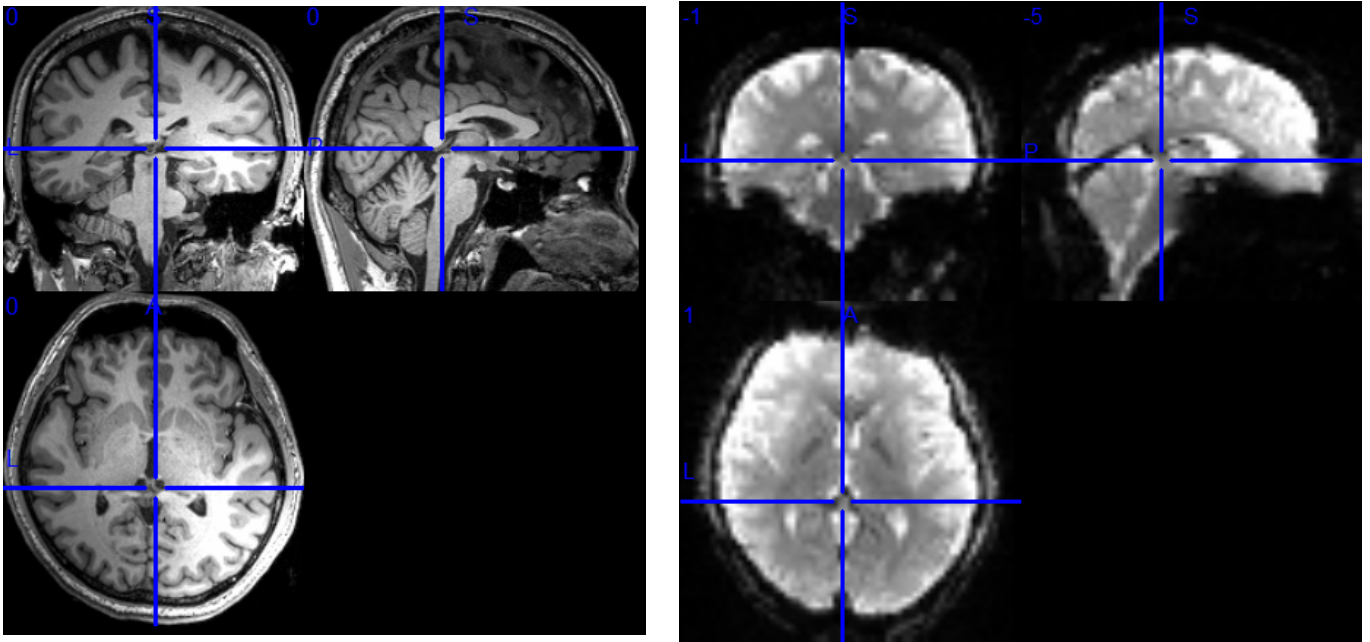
tRNS (1 mA, no filtering) results – MRI T1 (left) & MRI EPI (right)
